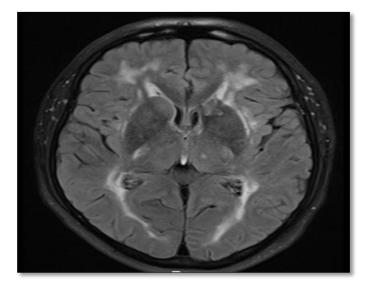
MRI of the brain (axial section through thalami/external capsules).
